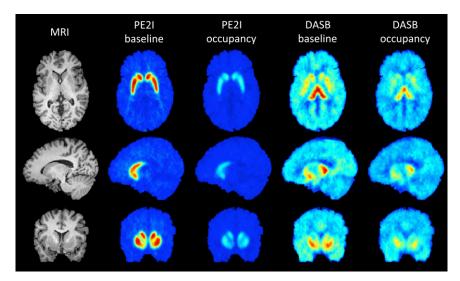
MR and mean PET images, before and after administration of SEP-225289 for the subject achieving highest serotonin transporter occupancy. Axial, sagittal, and coronal slices are shown in top, middle, and bottom rows, respectively. Left column shows MR images of subject, for anatomic reference. PET images are means of the last 6 frames of each scan (corresponding to last 60 min of scanning). Baseline scanning occurred 5-10 d before administration of SEP-225289. Difference in binding between baseline and occupancy scans is due to SEP-225289 transporter occupancy. Dopamine transporter occupancy in this subject (55%, as indicated by PE2I PET scans) was markedly higher than serotonin transporter occupancy (35%, as indicated by the DASB PET scans).
